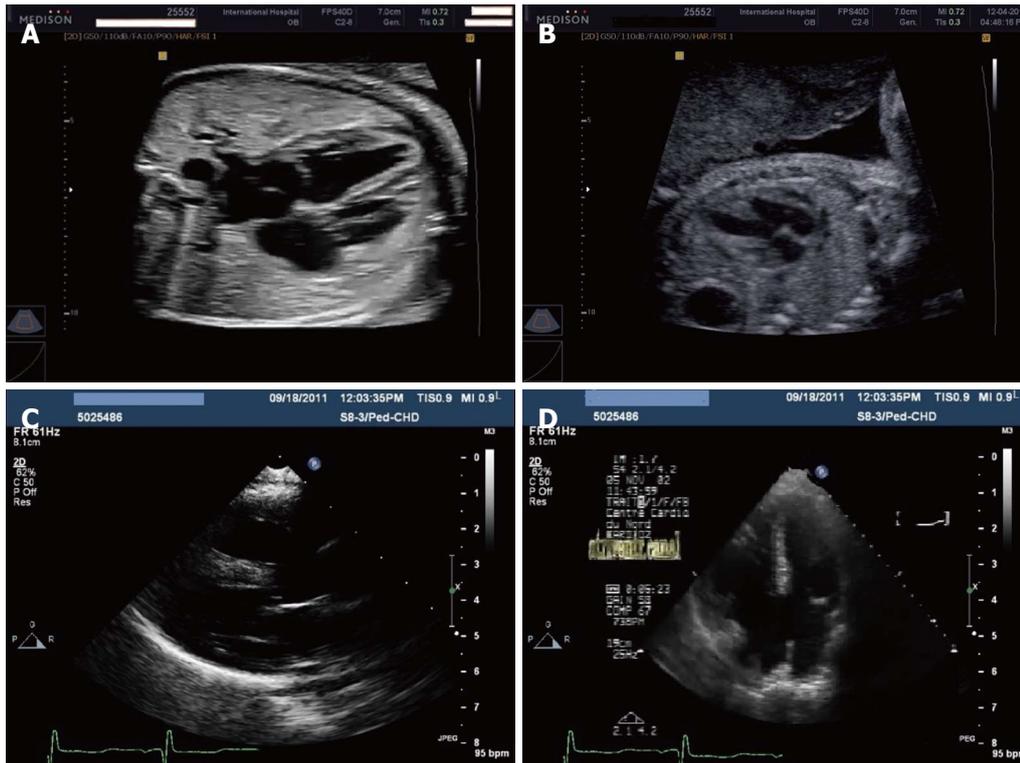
Ultrasonography. A: Normal 4-chamber view by fetal echocardiography at 26 wk gestation; B: Four-chamber view by fetal echocardiography at 22 wk gestation showing ventricular septal defects; C: Left-parasternal long-axis view in an infant with Down syndrome and complete atrioventricular (AV) canal and pulmonary hypertension; D: Apical 4-chamber view in an infant with Down syndrome and complete AV canal and pulmonary hypertension.
